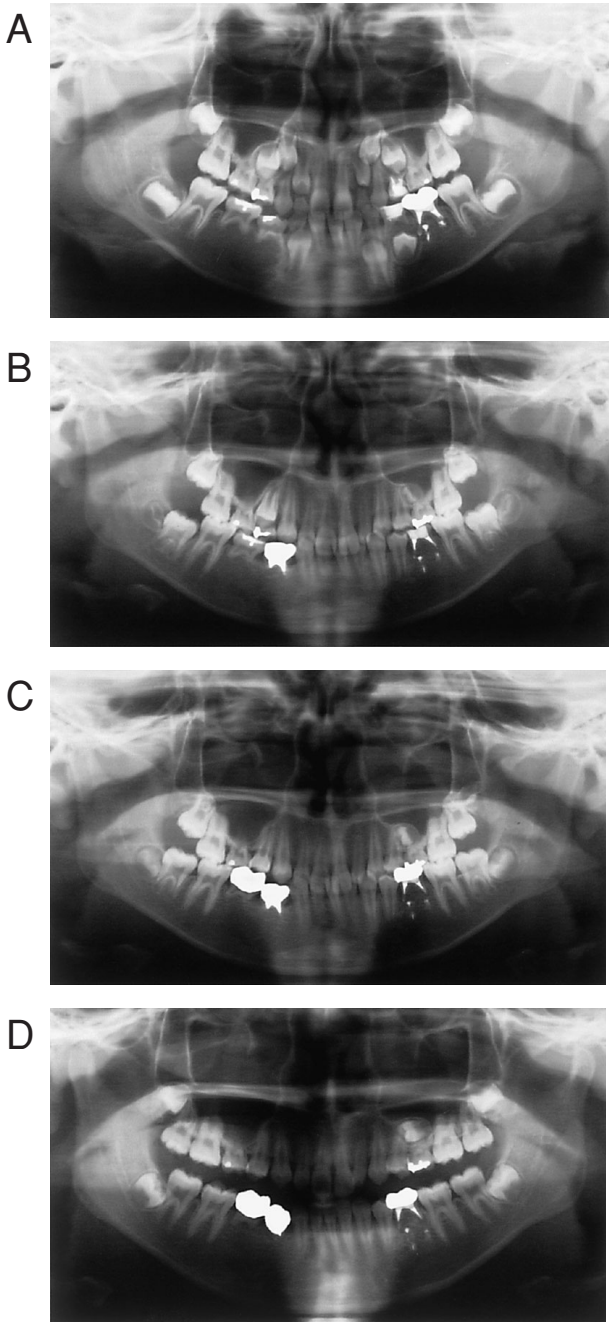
Orthopantomographs images taken at 7Y6M (A), 10Y3M (B), 11Y1M (C) and 14Y4M (D) in Case 1
